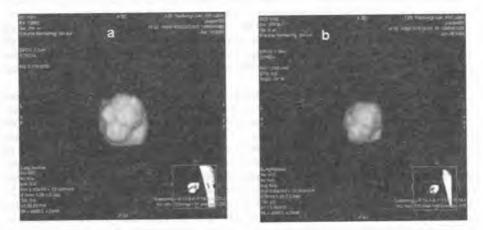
a, b. Images of a metastatic nodule in a 52-year-old man obtained with the 3D volumetric software; a – the first CT findings, b – 56 days later, the measured volume has decreased by 41%
